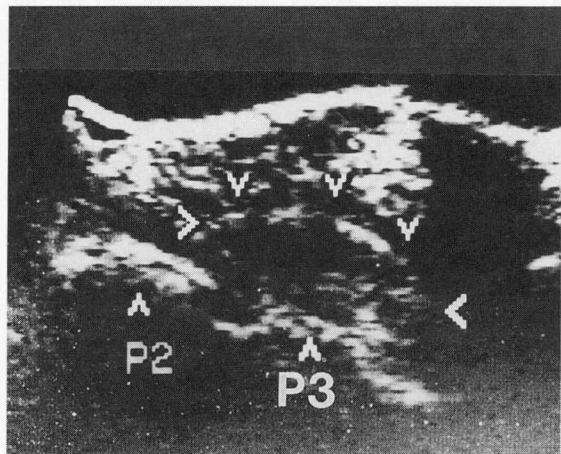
Ultrasonogram obtained via a 7.5-MHz sector transducer with offset. This is a long axis view over the dorsolateral aspect of the hoof at the level of the coronary band. A soft tissue mass (arrowheads) is visible between the hoof wall and the articulation of the middle and distal phalanges.
